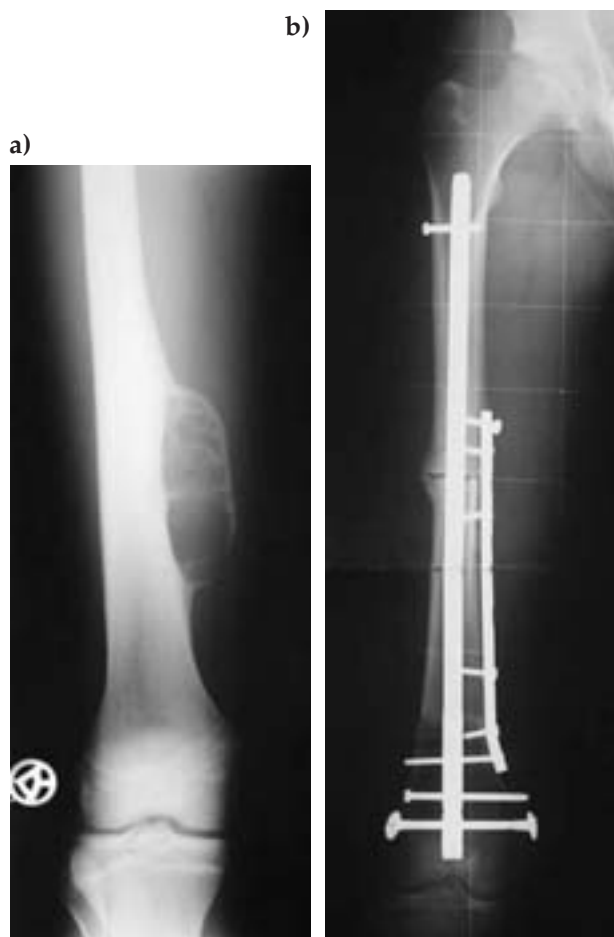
Radiographs of a 10-year-old boy with periosteal osteosarcoma localized in the femoral shaft (A). After "en bloc" resection reconstruction was performed with massive allograft, fixed with an unreamed femoral nail and plate and screws (B).
